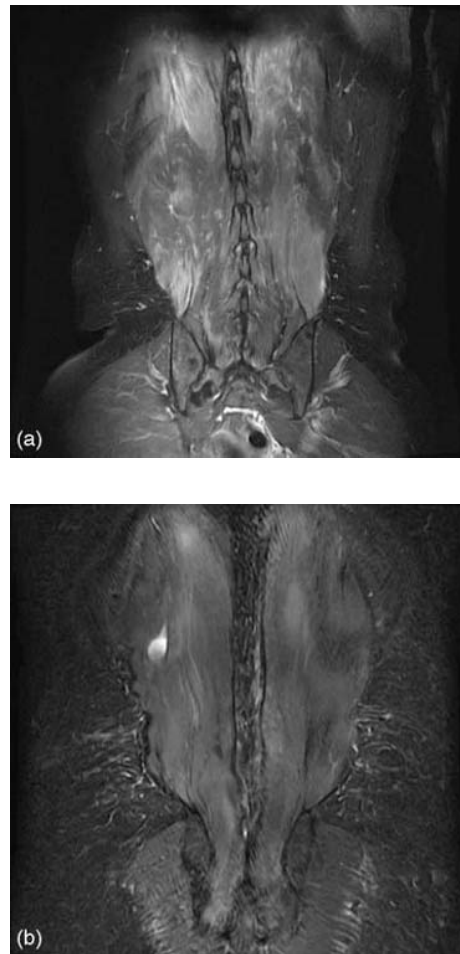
MRI of the erector trunci. (a) Fast T1 spin echo coronal section with fat suppression and after contrast medium injection. Heterogeneous gadolinium enhancement and patchy hyperintensities of the posterior bilateral paraspinal muscles, (b) Fast T2 spin echo coronal section with fat suppression. Same findings, plus swelling of the muscles and right-sided liquid necrosis zone. Reproduced from Diederich NJ, Goebel HH, Doms G, et al. (2006) Camptocormia associated with focal myositis in multiple-system atrophy. *Movement Disorders* 21: 390–394, with permission from ●●●.
